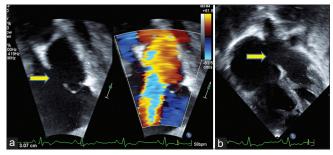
Echocardiogram in subcostal (a) and apical four-chamber view (b) showing secundum atrial septal defect (yellow arrow) with a thin aneurysmal inferior margin
